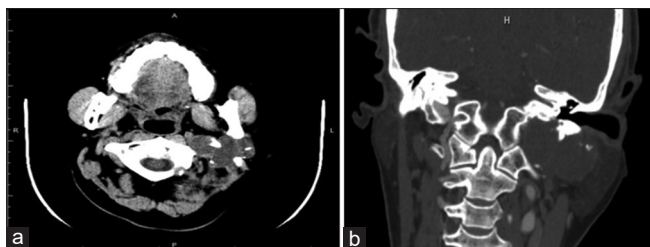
CT Scan showed an irregular lobular mass on the left parotid gland involving deep lobe with clear boundary and showing compression of the left internal jugular vein without cervical lymph nodes enlargement (a), The coronal incidence demonstrating a heterogeneous soft-tissue mass extended upon to the left temporal bone, and the boundary was not a rough (b)
